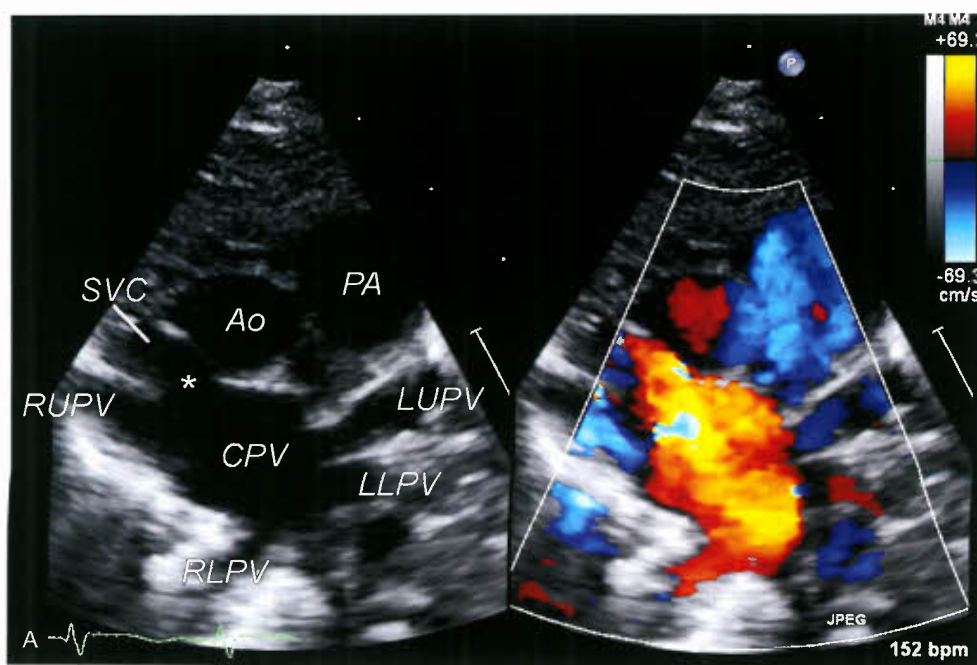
Echocardiographic delineation of totally anomalous pulmonary venous connection. A: High left parasternal transverse view of TAPVC to the right superior vena cava (SVC). The right upper pulmonary vein (RUPV), right lower pulmonary vein (RLPV), left upper pulmonary vein (LUPV) and left lower pulmonary vein (LLPV) are seen joining a horizontal pulmonary venous confluence (PVC). The vertical vein (asterisk) ascends rightward and anteriorly to join the posterior aspect of the SVC. The pulmonary artery (PA) is dilated secondary to the volume load. Ao, aorta.
